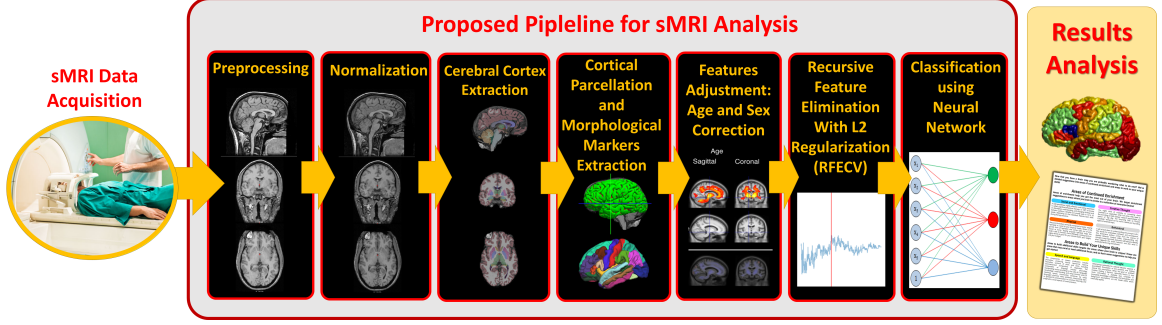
Overview of the proposed system starting from acquiring MRI volumes up to the diagnosis.
